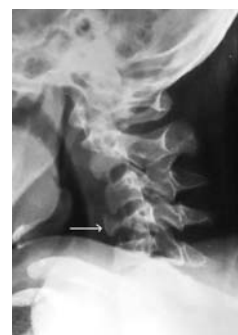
Plain Xray cervical spine showing burst fracture of C4 (arrow) with instability in flexion.
